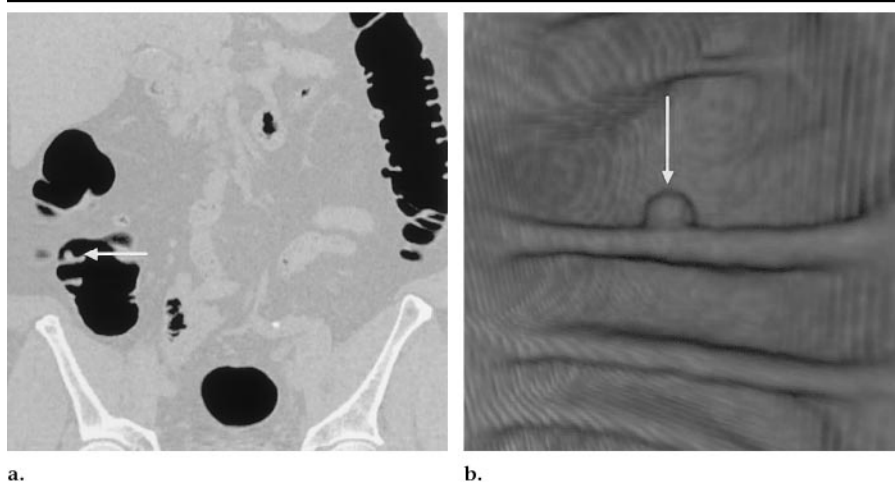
False-positive CT colonographic findings in 55-year-old man. (a) Coronal CT colonographic image shows a smooth round 6-mm mass (arrow) without an internal area of hyperlucency on the fold in the ascending colon. (b) Three-dimensional volume-rendered CT image of the mass seen in a shows a polypoid morphologic structure consistent with a polyp (arrow). At colonoscopy, no lesion was seen. Although we considered this lesion to be a false-positive finding, it is possible that it was a true polyp that was missed at colonoscopy.
